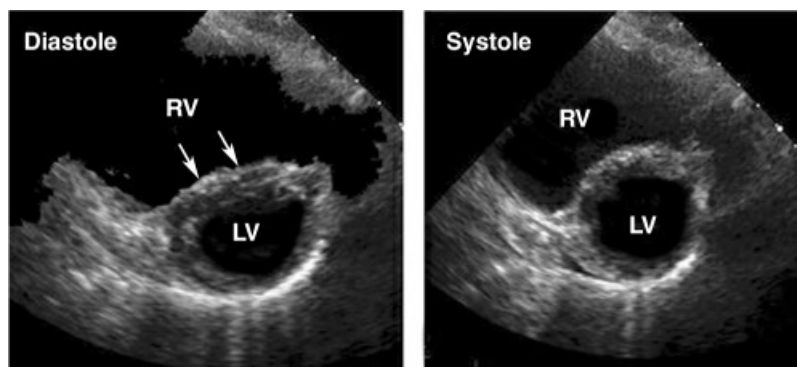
Transthoracic ultrasound image in the parasternal short-axis view showing right ventricular (RV) enlargement, where the RV cavity is larger than the left ventricular (LV) cavity. Note also that the interventricular septum is flattened during diastole (indicated by the arrows), which is a sign of RV volume overload. Image retouched from Reference 9.
